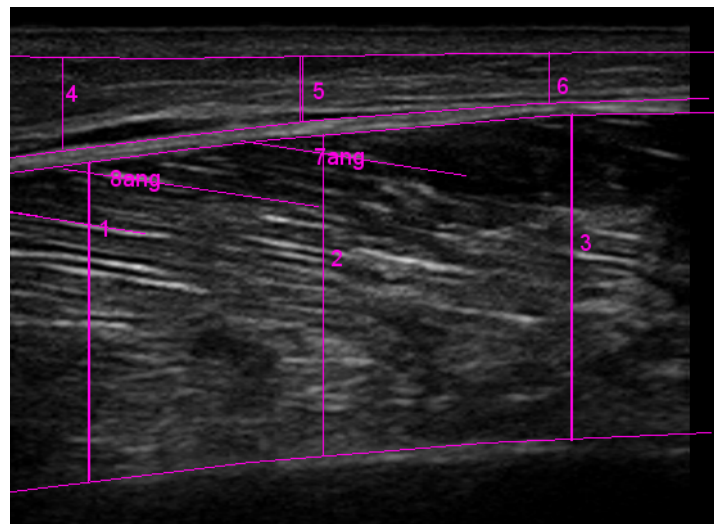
Example ultrasound image
